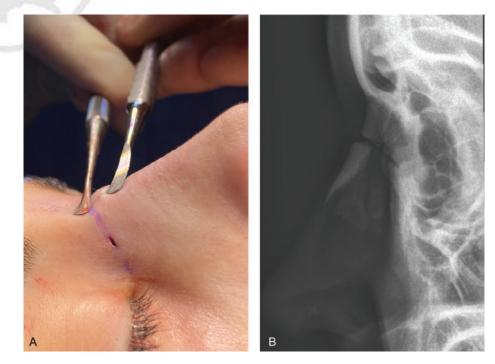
(A) The bony elevation created by the step-up technique. (B) Postoperative X-ray showing the step-up.
